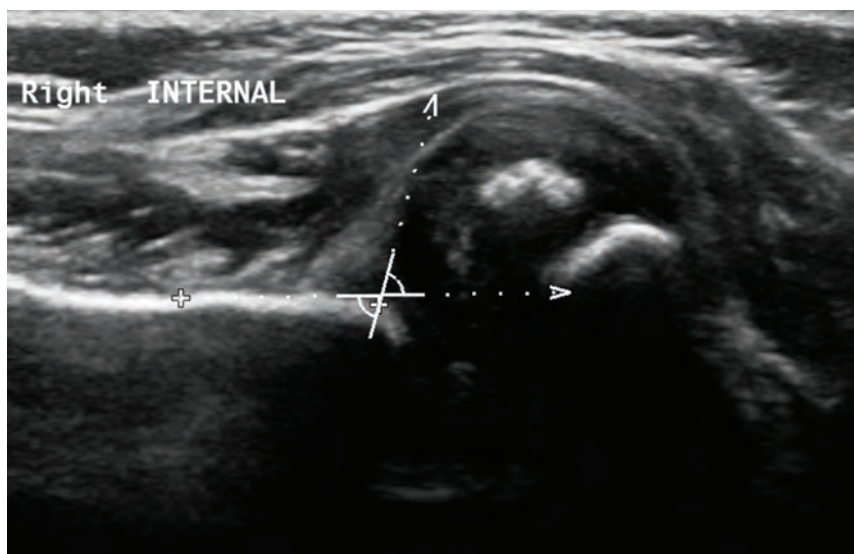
Shoulder ultrasound with severe subluxation. Lack of ossification makes the infant shoulder difficult to assess on X-ray. Ultrasound allows visualization of the humeral head and its relationship to the glenoid. In this view, the posterior border of scapula can be seen. A line from the posterior labrum that is tangent to the humeral head forms an angle as it intersects with the posterior border of scapula. This angle should be 30 degrees or less.
